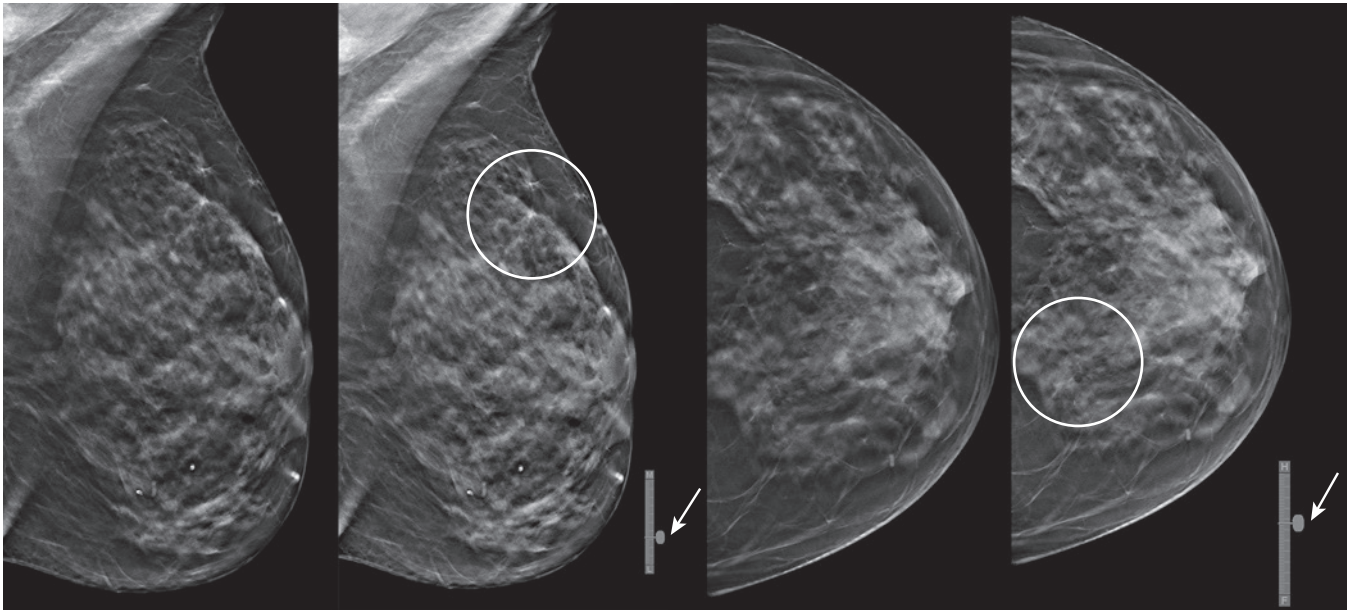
Pseudoarchitectural distortion. A 64-year-old woman referred for further evaluation of a possible architectural distortion (*circles*) seen on tomosynthesis mammogram performed at an outside facility. From the localizer bars (*arrows*), the lesion would be located in the *upper outer* part of the breast on the ML view (slice 18 of 51) and the *upper inner* area on the CC view (slice 33 of 57), and therefore clearly not representing the same lesion. Repeat tomosynthesis imaging was performed and no architectural distortion was reproduced. Whole breast ultrasound was also normal. BI-RADS 2.
